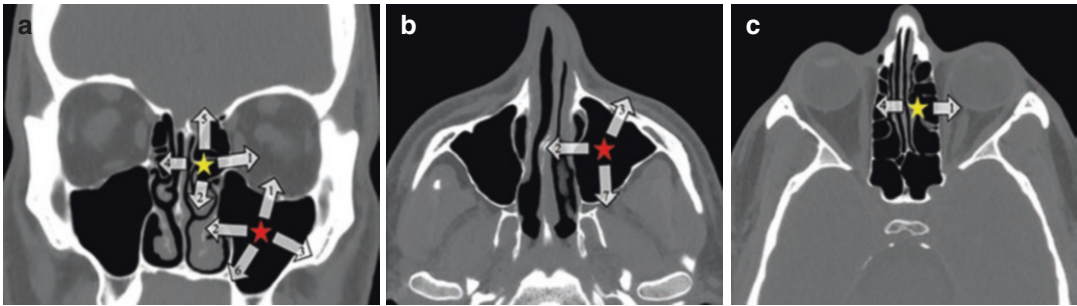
Potential directions of growth of ethmoidal (yellow star) and maxillary (red star) tumours in different CT scan views ((a), coronal; (b) axial at the level of maxillary sinuses; (c) axial at the level of the orbits). Legend: 1 orbital infiltration; 2 nasal cavity extension; 3 anterior/
